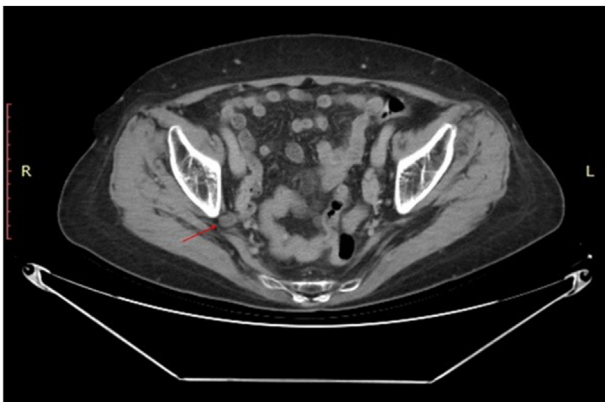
Preoperative CT showed that the ureter herniated into the greater sciatic foramen.
